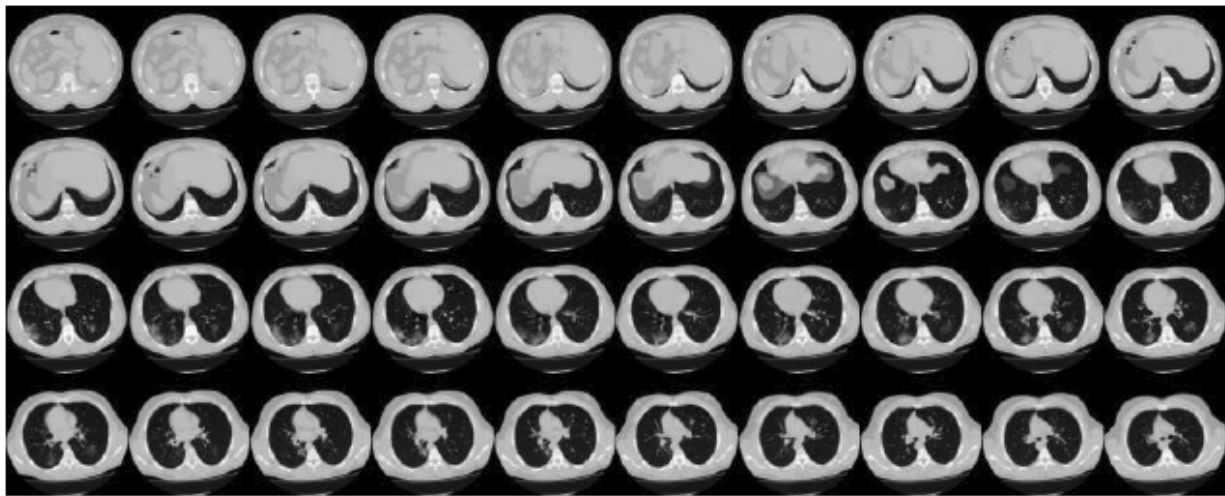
First 40 slices from a CT volume (MosMedData)
